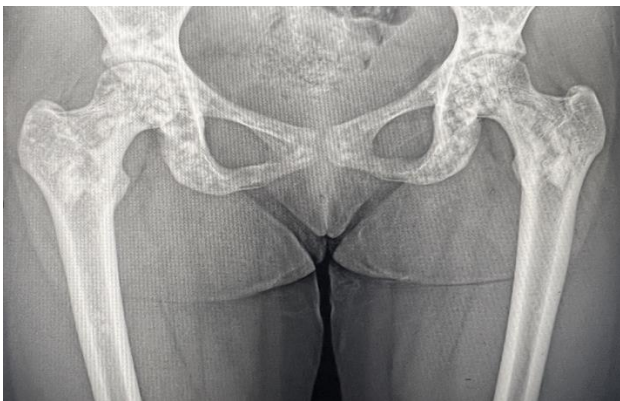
Pelvis with both hips radiograph.
